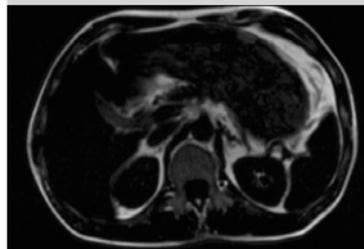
Image reconstruction. Algorithm for fast MR image reconstruction from raw data.
